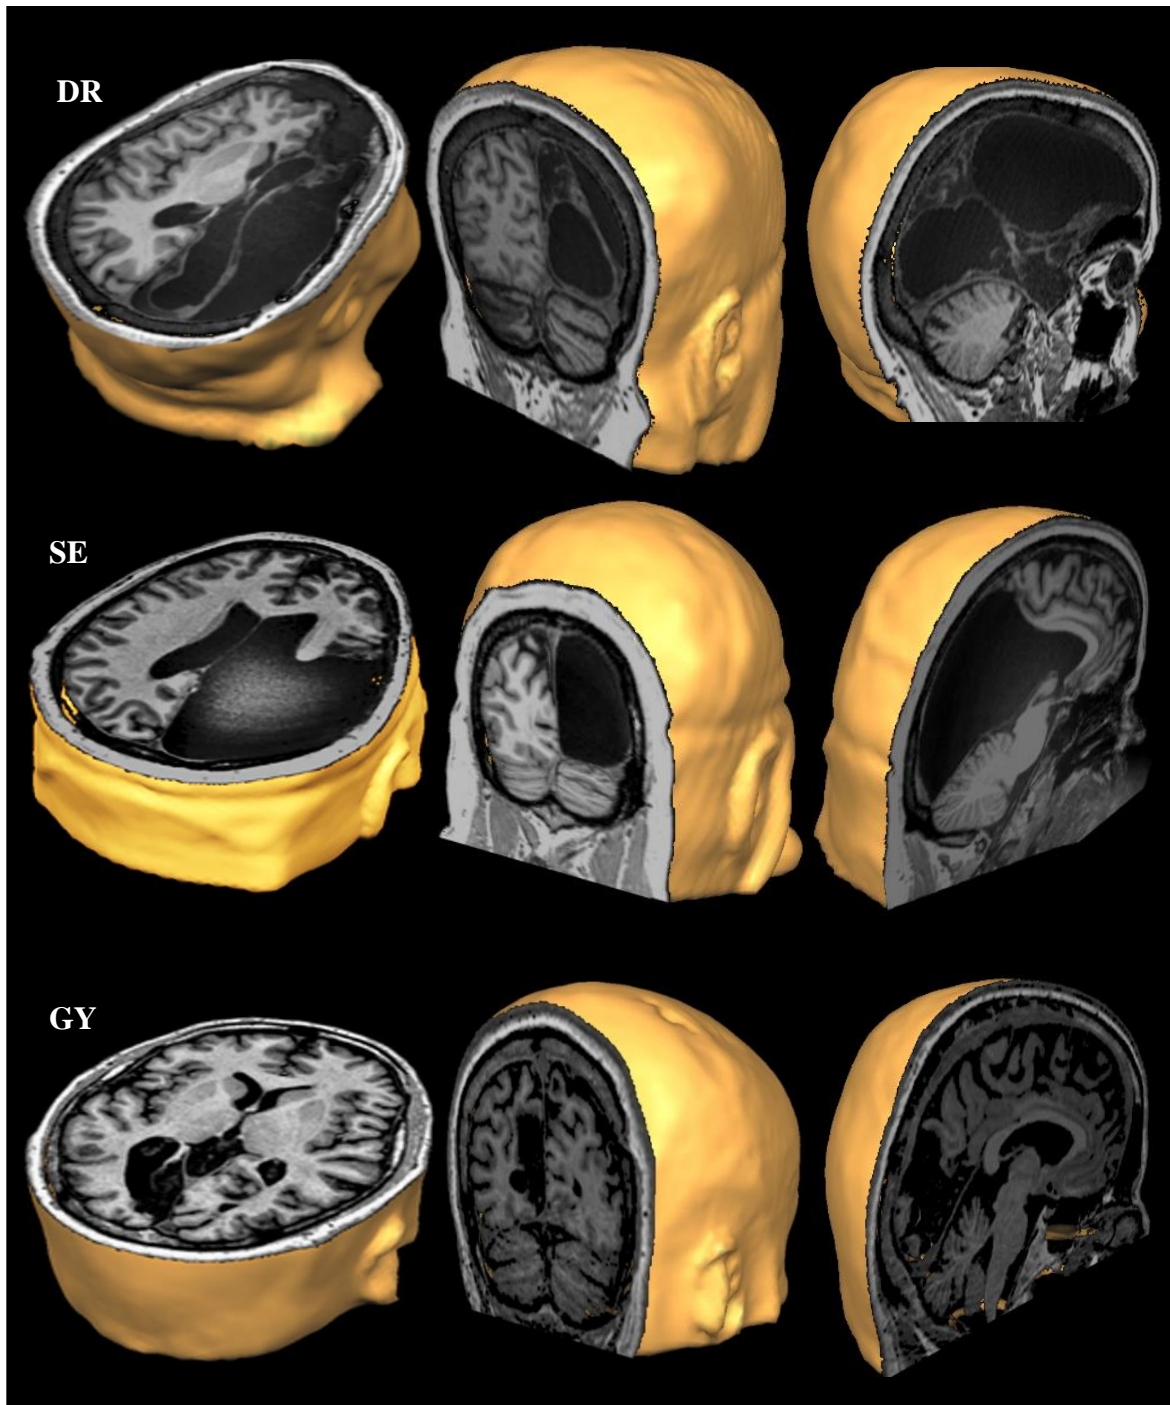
Blindsight Patients' T1-weighted MRI
